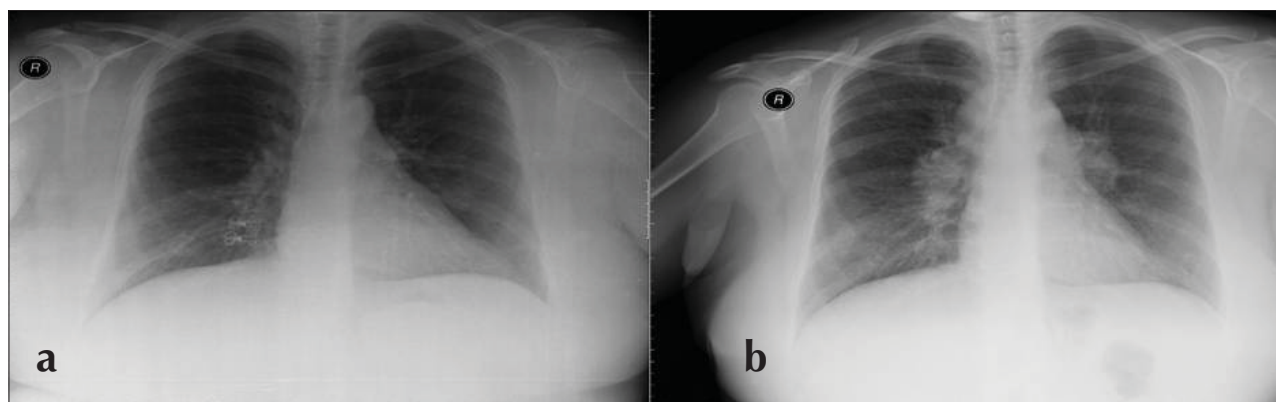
a, b. Plain chest X-ray of the patient: (a) before treatment of CS and (b) after treatment of CS. CS: Cushing syndrome.
